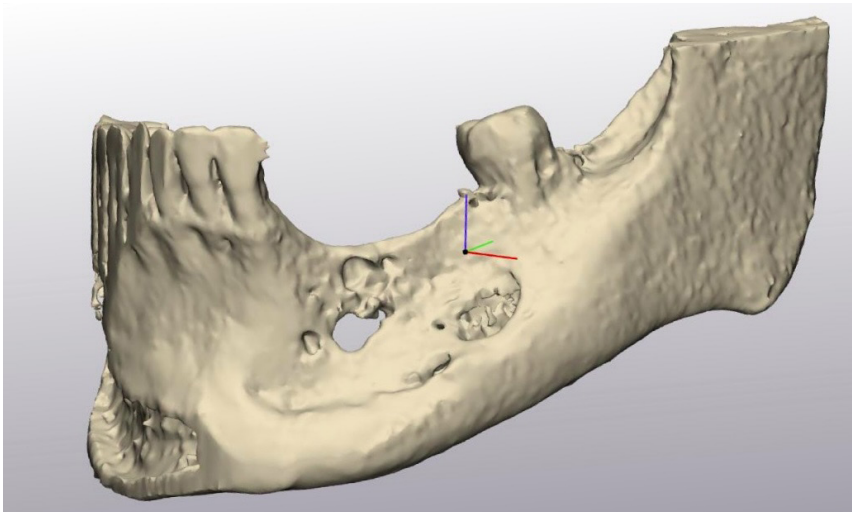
Evaluation of the 3D CT model of the surgical site for custom mesh production*
